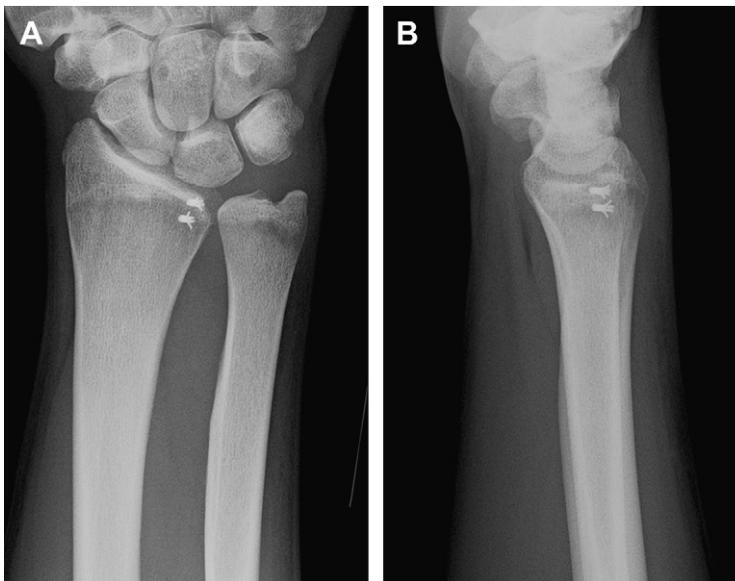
(*A*) Repair of the ruptured dorsal distal radioulnar ligaments was performed with two suture anchors into the distal radius. (*B*) The lateral radiograph reveals a concentrically reduced DRUJ.
